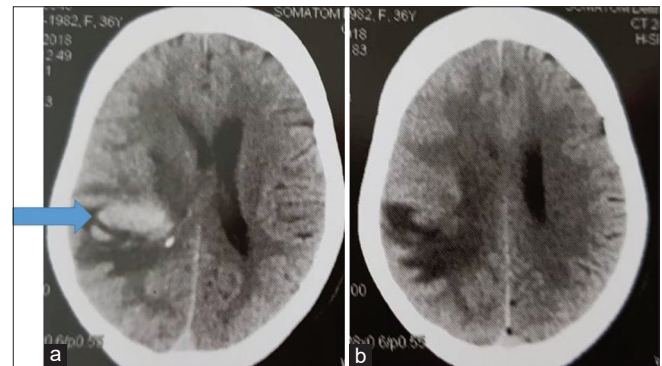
(a and b) Noncontrast computed tomography of the brain showing resolving bleed in the right parietal lobe with surrounding edema extending into basal ganglia and mass effect (arrow)
